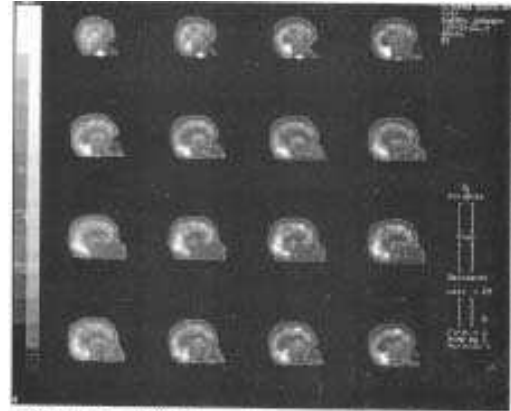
Patient no. (5): Follow up after 6 months SPECT scanning showed normal findings (Sagittal view).
